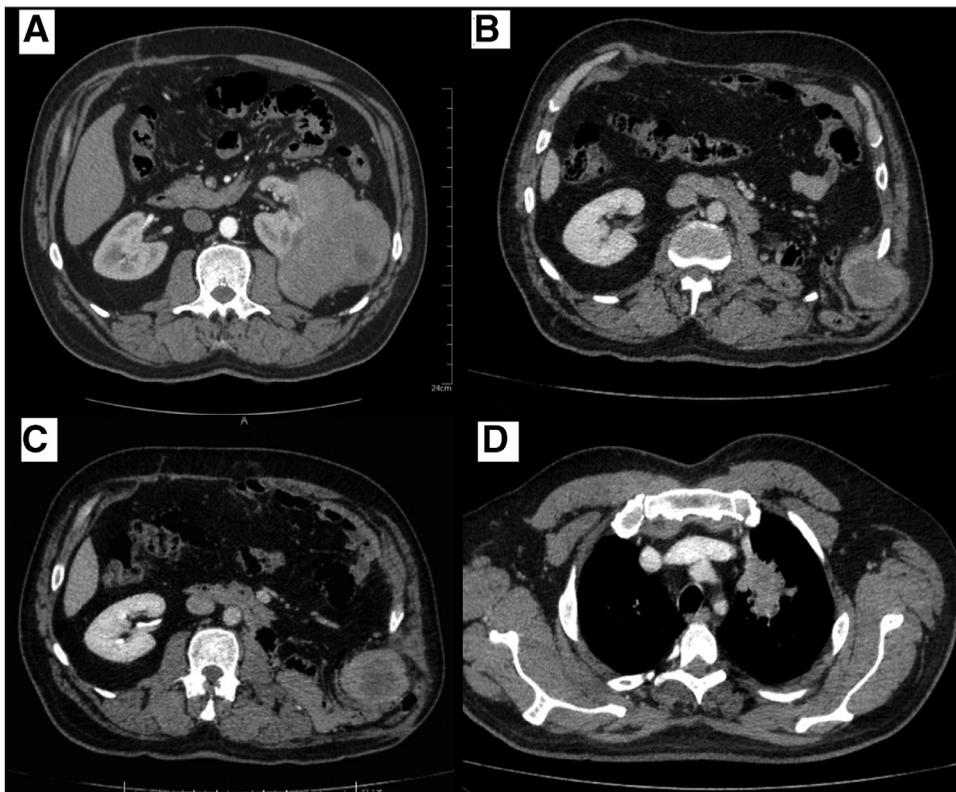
Axial contrast-enhanced computed tomography images. (A) Primary tumor: a lobulated well-circumscribed mass along the lateral aspect of the mid-pole of the left kidney with heterogeneous enhancement and areas of necrosis measuring 13 cm. (B) First local recurrence: a mass of 6 cm with heterogeneous enhancement and central necrosis in the nephrectomy lodge. (C) Second local recurrence: another mass of 6 cm in the same previous location with heterogeneous enhancement and central necrosis. (D) Pulmonary metastasis: a left lung apex soft-tissue mass with irregular margins measuring 6 cm.
